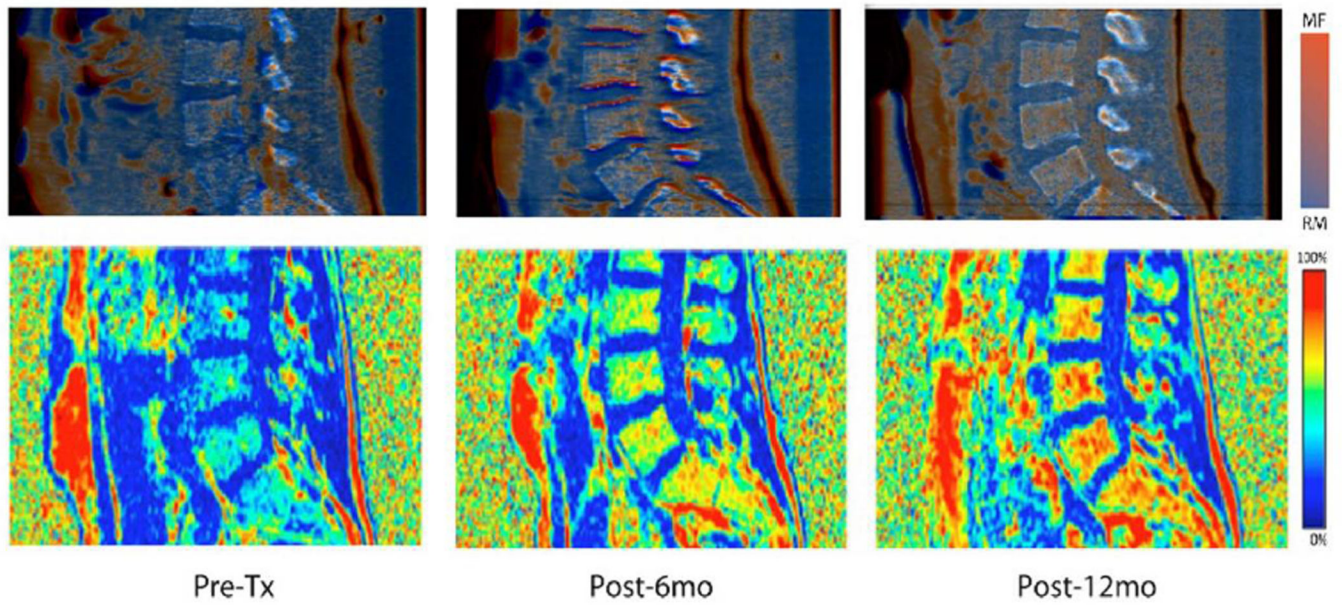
Marrow fat mapping of a representative patient using DECT and water-fat MRI
